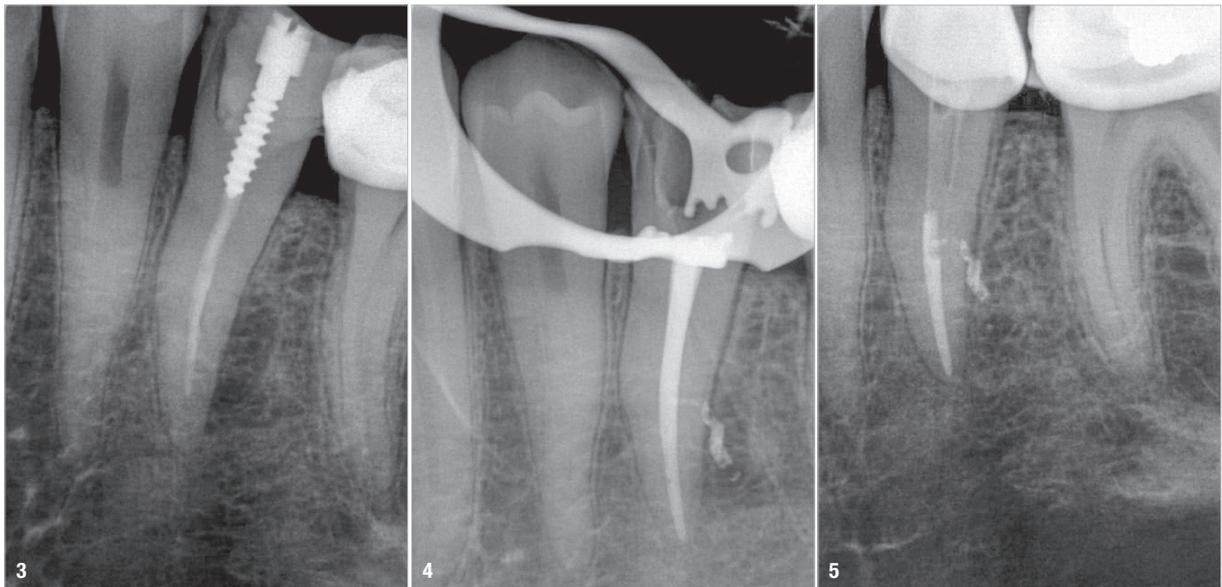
Pre-op radiograph of tooth #35. Incomplete endodontic obturation and a metal post were visible. A radiolucent periradicular lesion was detectable laterally on the distal aspect of the root. Fig. 4: Final radiograph of the endodontic retreatment (with the dental dam still on the tooth) showing complete and compact filling of the endodontic space, including the filling of a lateral canal and a little extrusion of sealer though it in the site of the lateral radiolucent lesion. Fig. 5: Follow-up radiograph at one year of the endodontic retreatment of tooth #35. Healing of the lateral radiolucent lesion confirmed the success of the endodontic retreatment performed with HyFlex Remover and EDM files activated by CanalPro Jeni.
